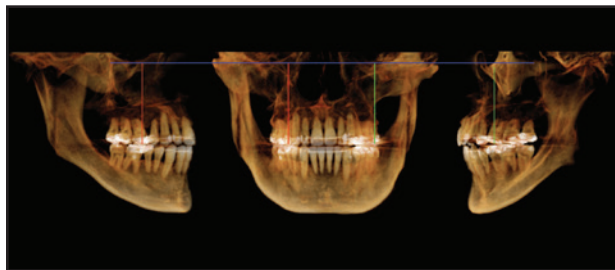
(cont.) B. Superimposition of pre- and post-treatment cephalometric tracings. C. Cone-beam computed tomography images confirming symmetry of maxillary height, ramal (1) and mandibular body (2) lengths, chin height, mandibular midline to gonion, and ramal inclination (lateral and rear views).^{7,50}
